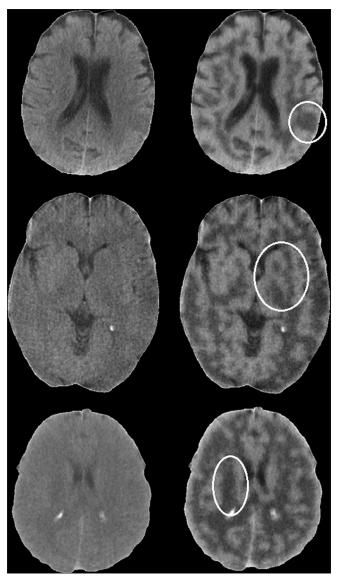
Three pathologic brain CT images enhanced using proposed method. Left: Original image. Right: Enhanced image
